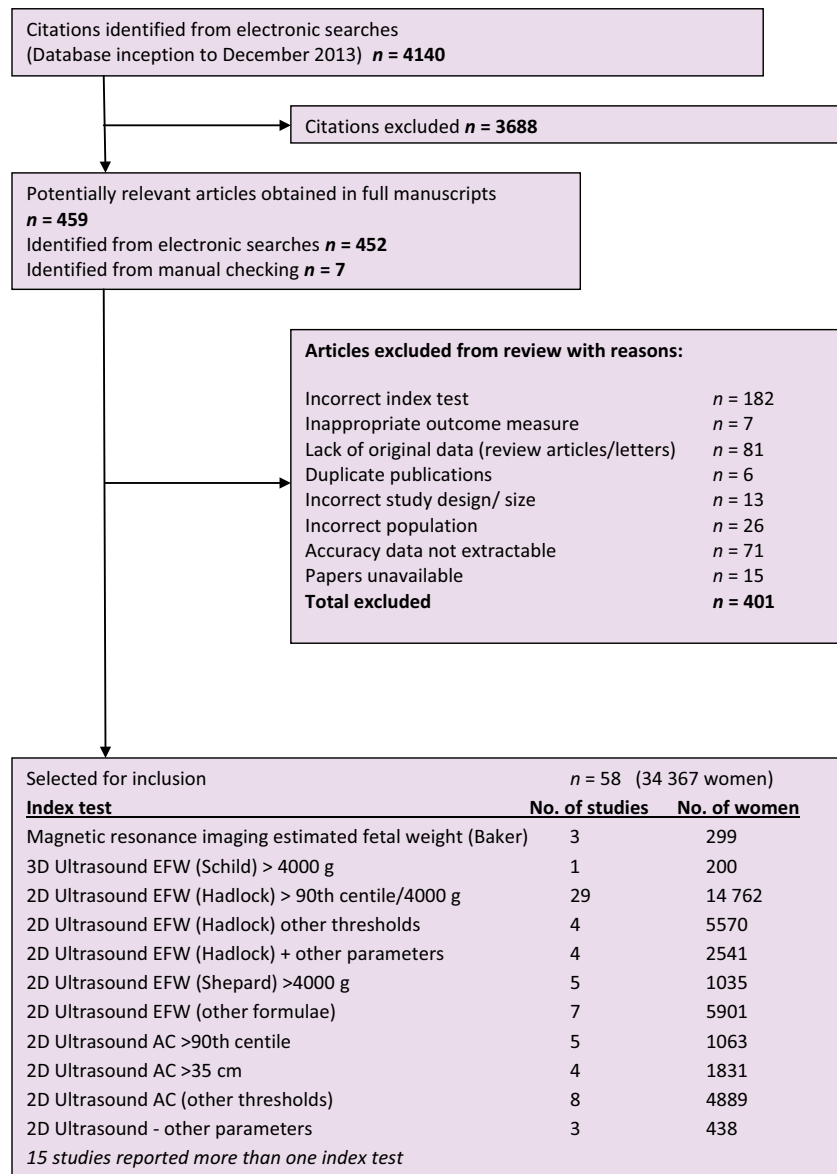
Study selection process for systematic review of the diagnostic accuracy of antenatal ultrasound and MRI scan for fetal macrosomia at birth.
